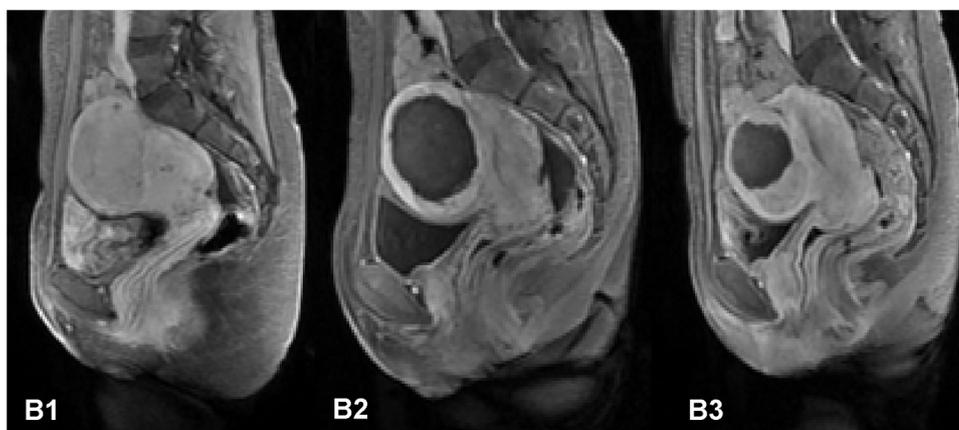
contrast-enhancement sagittal MRI before and after USgHIFU treatment: (B1) fibroid shows enhanced slightly before treatment; (B2) the NPV is visible inside uterine fibroid on contrast-enhanced MRI immediately after treatment; (B3) the fibroid size shrink obviously although the NPV ratio decrease than 6 months before on contrast-enhanced MRI.
